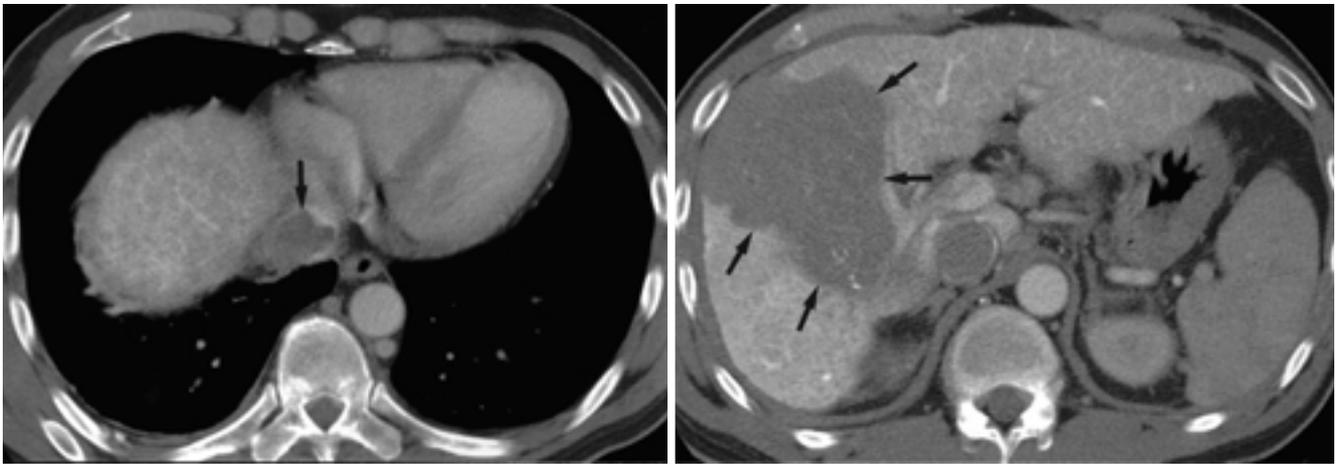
A, B. CT during arterial portography shows a large perfusion defect (arrows) at the right hepatic lobe and within the inferior vena cava. In CT during hepatic arteriography, this perfusion defect shows good enhancement (not shown here). This indicates that the tumor extends through hepatic vein into the inferior vena cava.
